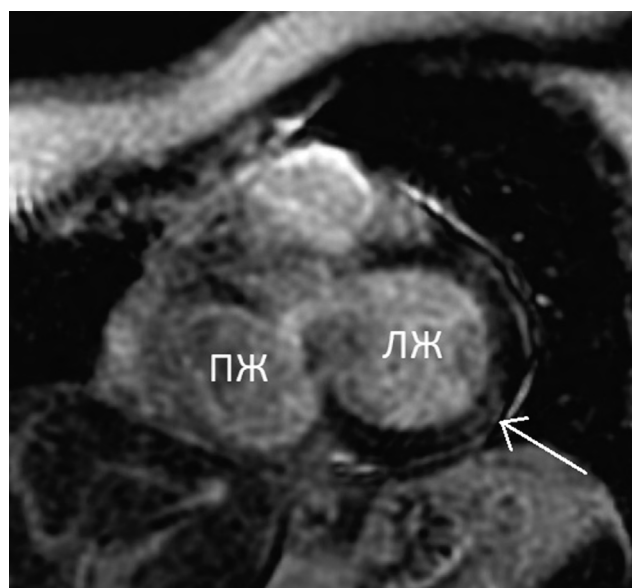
Cardiac MRI, short axis at the level of the basal segments. Late gadolinium enhancement. The arrow indicates an intramural non-ischemic zone of contrast accumulation at the border of 4 and 5 left ventricle segments. ПЖ — right ventricle; ЛЖ — left ventricle
